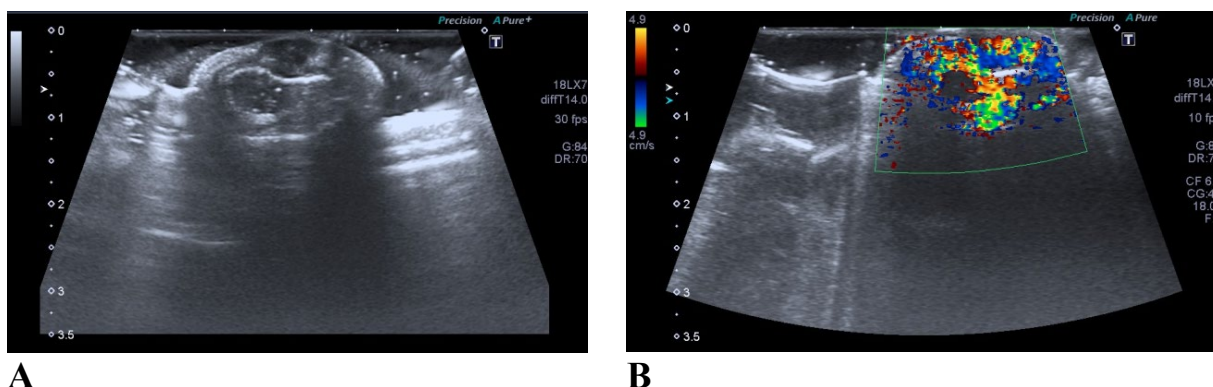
The ultrasound examination of the combined cavernous hemangioma of the right auricle prior to surgical treatment. A — a hypoechoic formation of about 8x3.7 mm in size is determined, the contours are clear, the contents are heterogenous. The surrounding tissue without visible changes. B — color Doppler imaging: the blood flow is pronounced, the rate of blood flow is sharply increased
